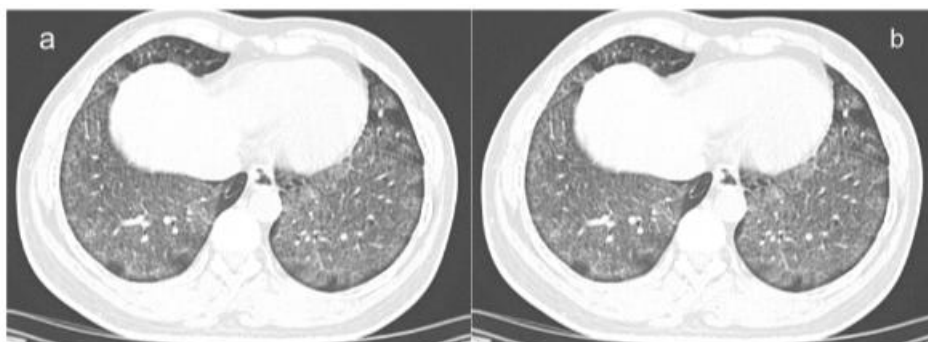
HRCT showing bilateral (a) lower lobe (b) right middle lobe and Lingula crazy pavement pattern at presentation
